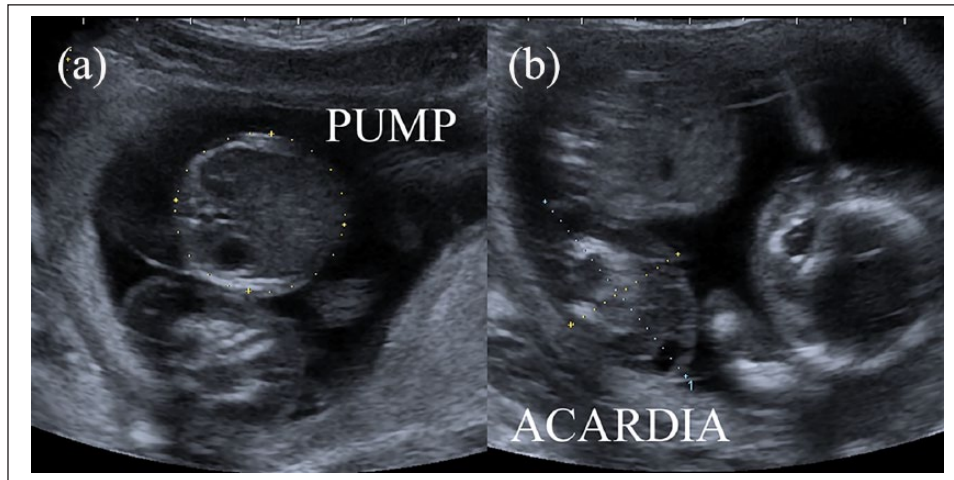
Abdominal ultrasound images at 16 weeks' gestation. Calculated waist of the pump twin from the abdominal circumference (a), and that of the acardiac twin from the transverse trunk diameter and antero-postero trunk diameter (b).
